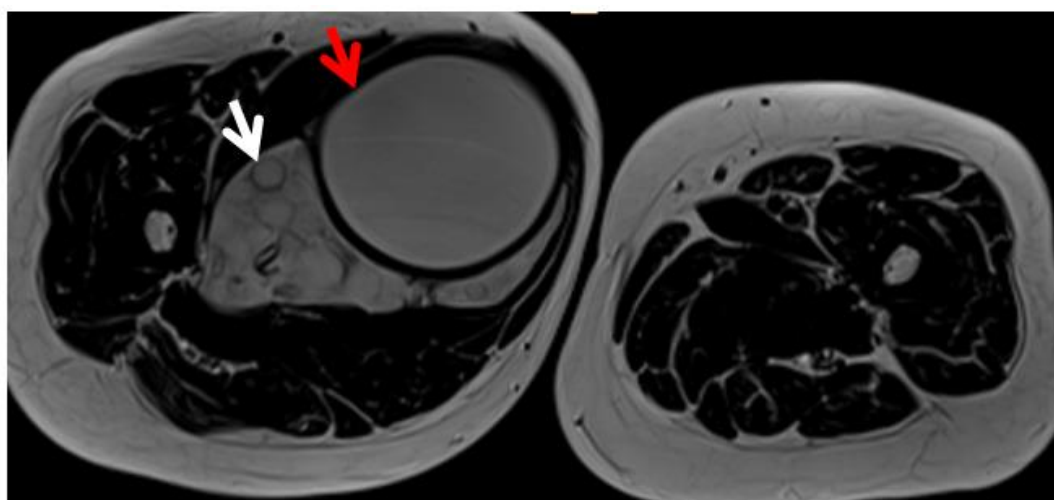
MRI. Axial T2-weighted image: cystic formation containing multiple daughter vesicles with hyperintensity (white arrow) and a hypointense pericystic rim (arrow)
